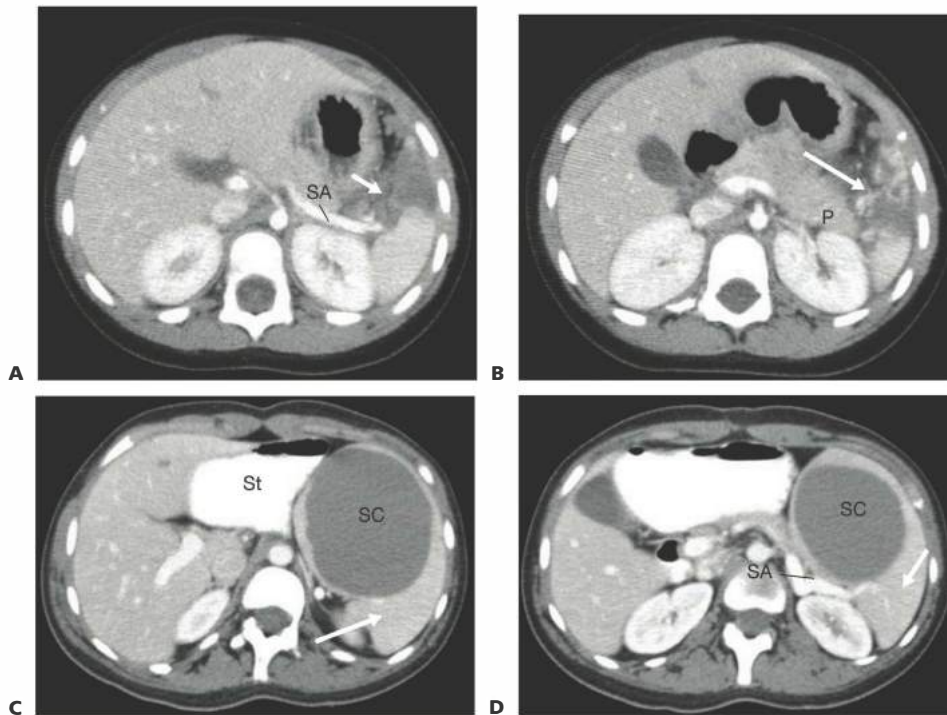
• CT scan of splenic laceration (A,B) and splenic cyst (C,D). A. CT demonstrating isolated injury to the spleen (*white arrow*) from blunt abdominal trauma with hemoperitoneum. Note the proximity to the splenic artery (SA). B. CT from same patient demonstrating extent of splenic injury (*white arrow*) extending to inferior pole. Note the proximity of the spleen to the tail of the pancreas (P). C. CT demonstrating a large splenic cyst (SC) compressing normal splenic parenchyma (*white arrow*). The cyst is compressing the stomach (St). D. CT image from same patient demonstrating the relationship of the SC to the SA. This patient underwent successful laparoscopic PS with preservation of normal splenic parenchyma. *Large white arrow*, splenic laceration; *narrow white arrow*, normal spleen.
